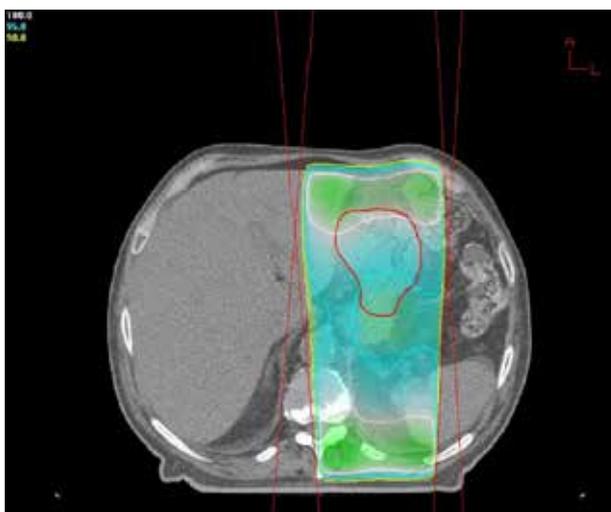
Axial image of AP and PA X-ray beams treating the gastric melanoma.
